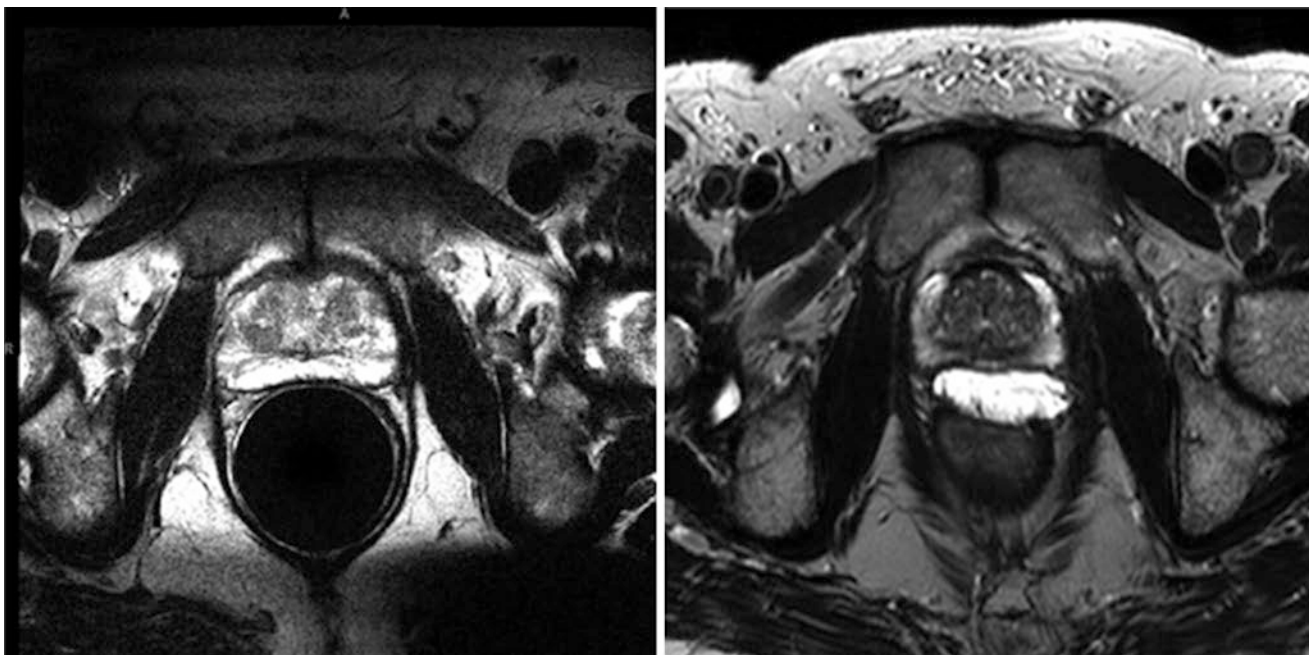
Visual comparison of the rectal balloon vs the spacer gel in 2 similar patients. Left: Representative T2-weighted axial MRI obtained using a 3 T magnet in a patient with a radiation therapy endorectal balloon in place. Right: Representative T2-weighted axial MRI obtained
